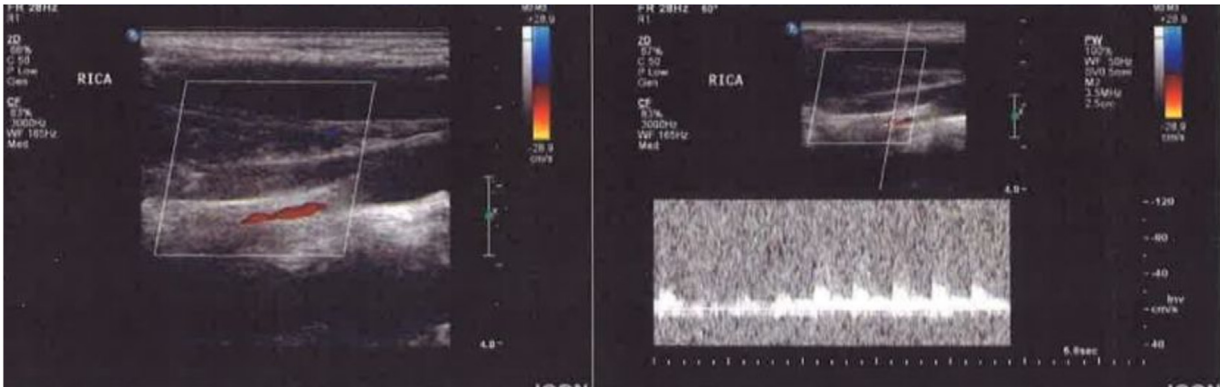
Color flow imaging and Doppler spectra of the right internal carotid artery (ICA) demonstrating diffuse luminal narrowing of the left ICA 1 cm distal to the carotid bifurcation (Left) with reduced peak systolic flow velocity (~ 40 cm/s; Right).
